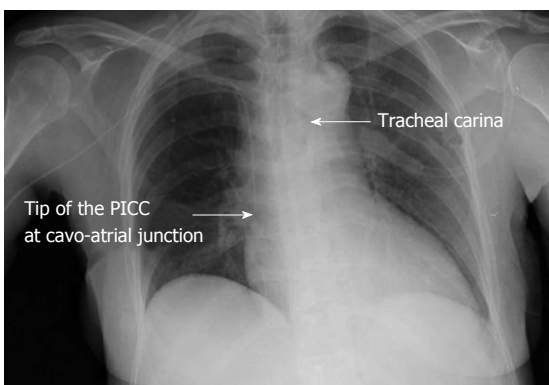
Post-procedural chest X-ray. The left arrow shows the tip position of the peripherally inserted central catheter (PICC) that is at cavo-atrial junction (between the superior vena cava and the right atrium). The right arrow shows the tracheal carina.
